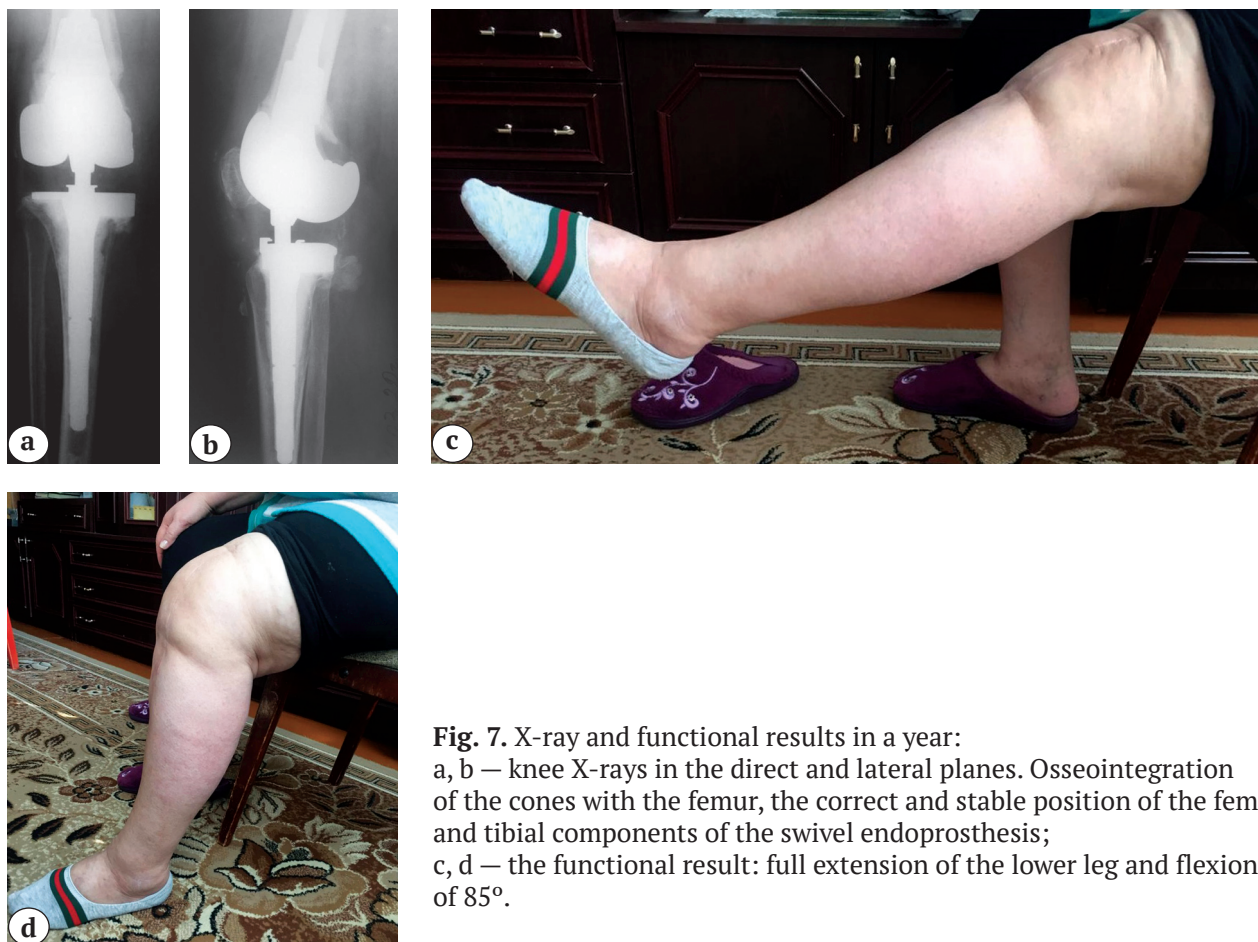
X-ray and functional results in a year:
